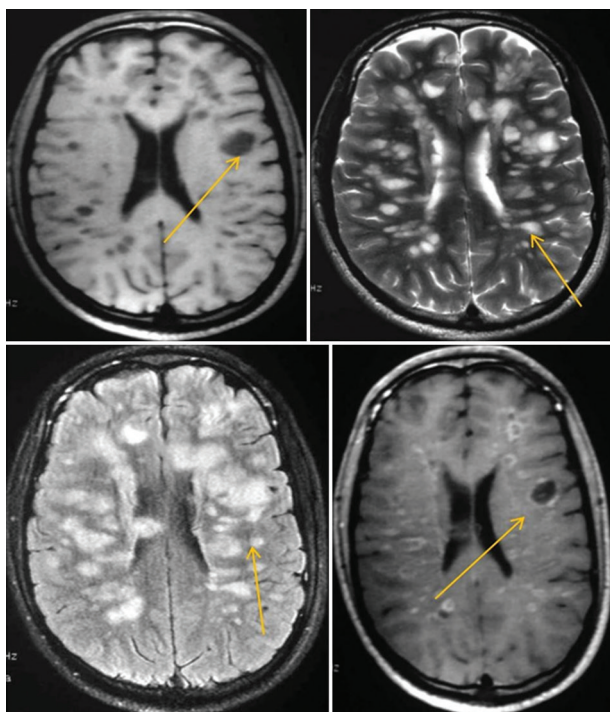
The brain MRI revealed multiple discrete and confluent altered SI lesions with a peripheral rim of enhancement in both bilateral cerebral hemispheres (indicated by yellow arrows)
